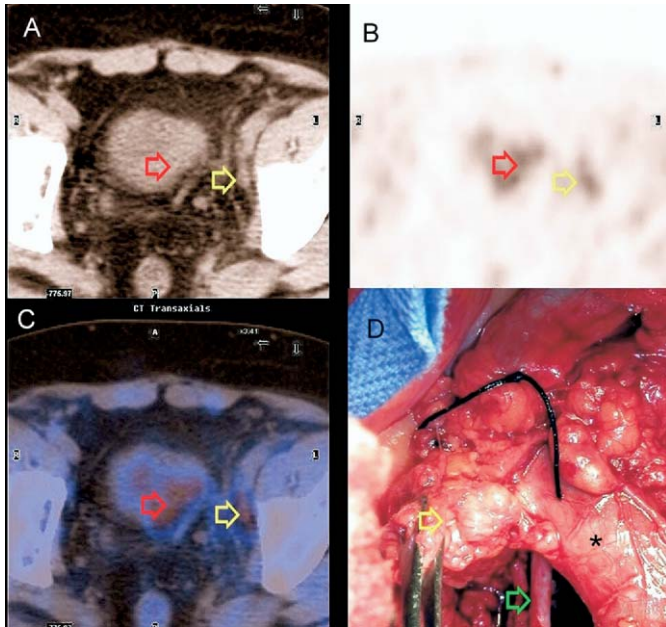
Case 1. PET/CT axial images of pelvis. A to C, CT, PET and superimposed CT and PET at level of bladder base. Primary tumor (red arrow) and 8 mm lymph node (yellow arrow) are visualized on PET. D, intraoperative view. Involved lymph node is held by pin-cette (yellow arrow). External iliac vein is marked by asterisk and obturator nerve by green arrow. Ligated ureter is recognizable by stitch.
